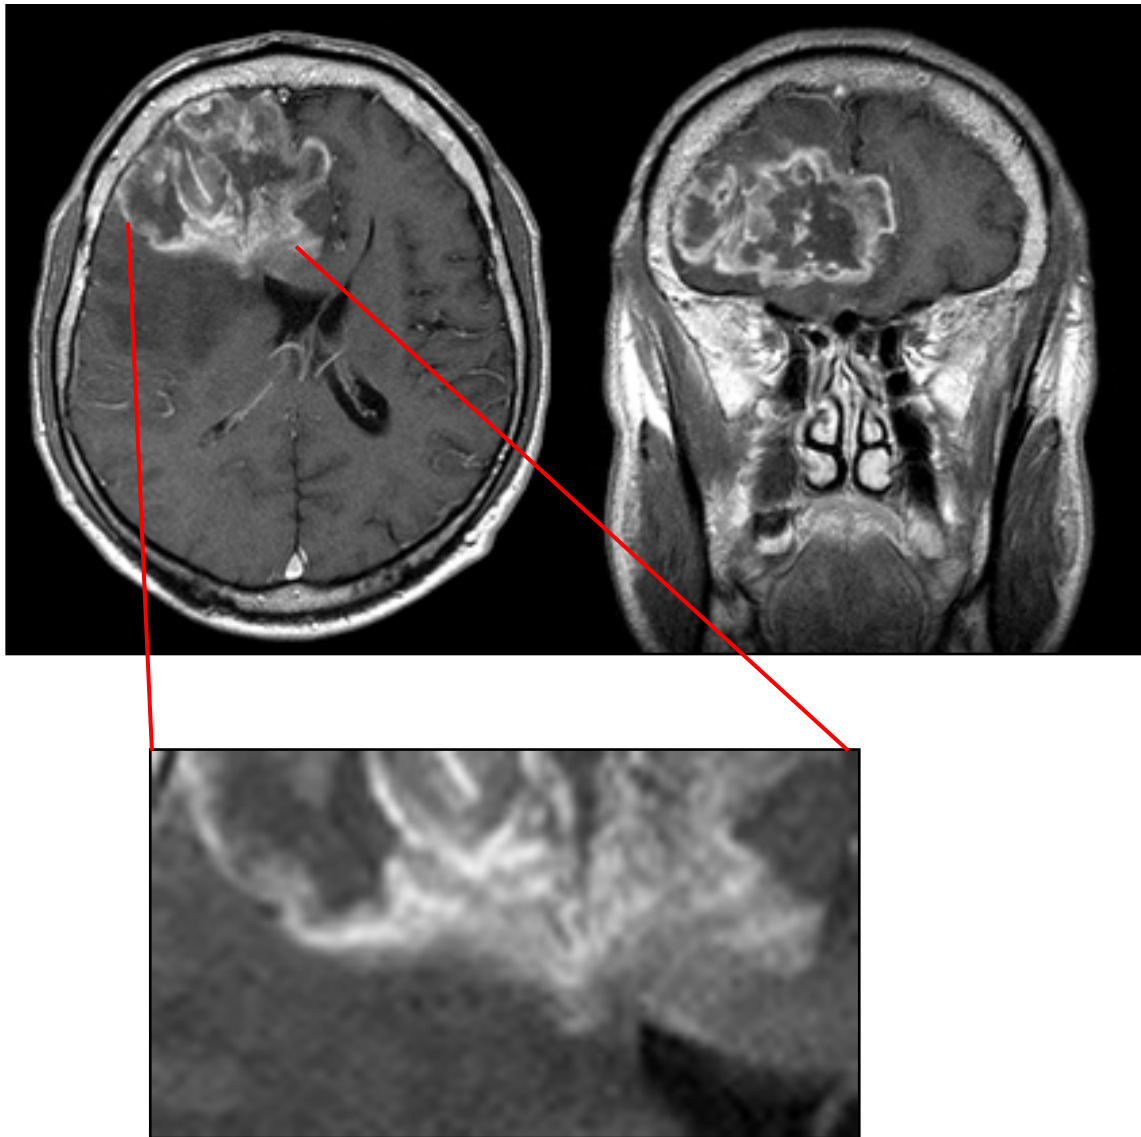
MRI with contrast enhancement showing the infiltration zone of a glioblastomas.
